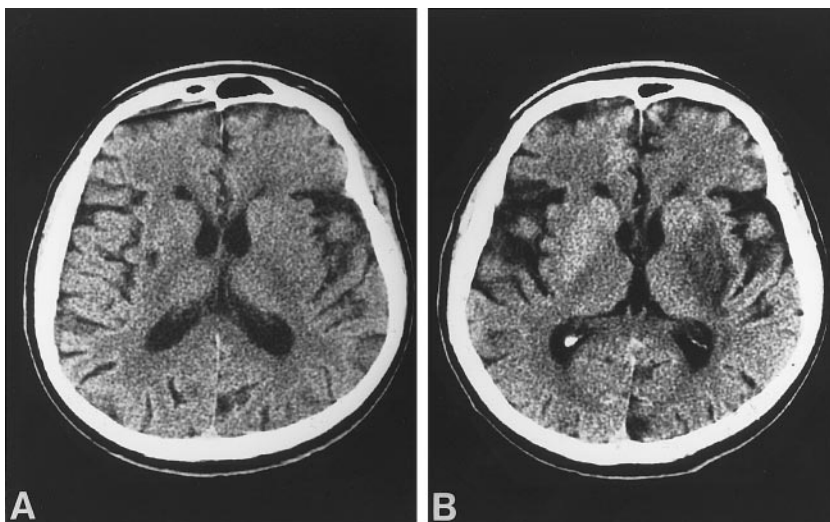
Noncontrast CT scans at baseline (A) and 8 days after presentation (B) in a 70-year-old man with acute right hemiparesis and aphasia who underwent angiography 3.4 hours after symptom onset. A, An old right putamen lacune is evident, but the left hemisphere appears normal. Subtle evidence of edema can be appreciated in the left lentiform nucleus. B, There is a new left lentiform nucleus infarction, but the remainder of the MCA territory appears normal.
